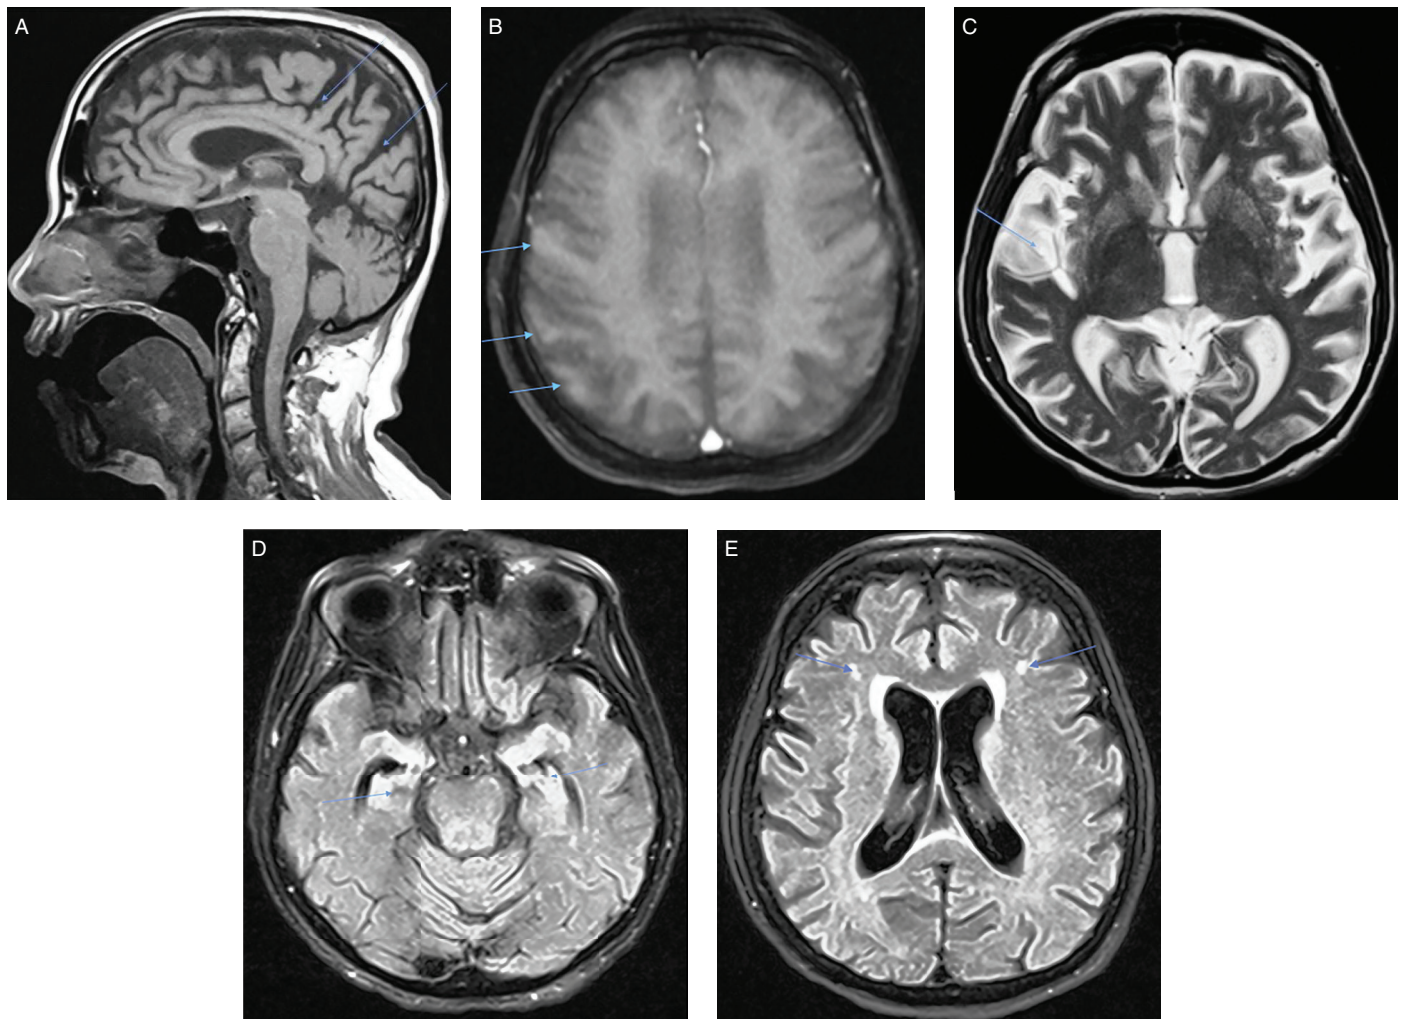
Photographs of the MRI scan of the brain of the patient with SSPE. (A) Sagittal magnetic resonance imaging (MRI) T1-weighted image of the brain showing diffuse atrophy. (B) Axial T1-weighted post-IV gadolinium showing mild subcortical enhancement in the right parietal lobe (blue arrows). (C) Axial MRI T2-weighted image of the brain showing asymmetric hyperintensities best noted in the right temporoparietal region (blue arrows). (D) Axial MRI T2-FLAIR-weighted image of the brain showing diffuse hyperintensities in mesial temporal lobes bilaterally (blue arrows). (E) Axial MRI T2-FLAIR-weighted image with hyperintensities best seen in the frontal lobes (blue arrows) bilaterally.
